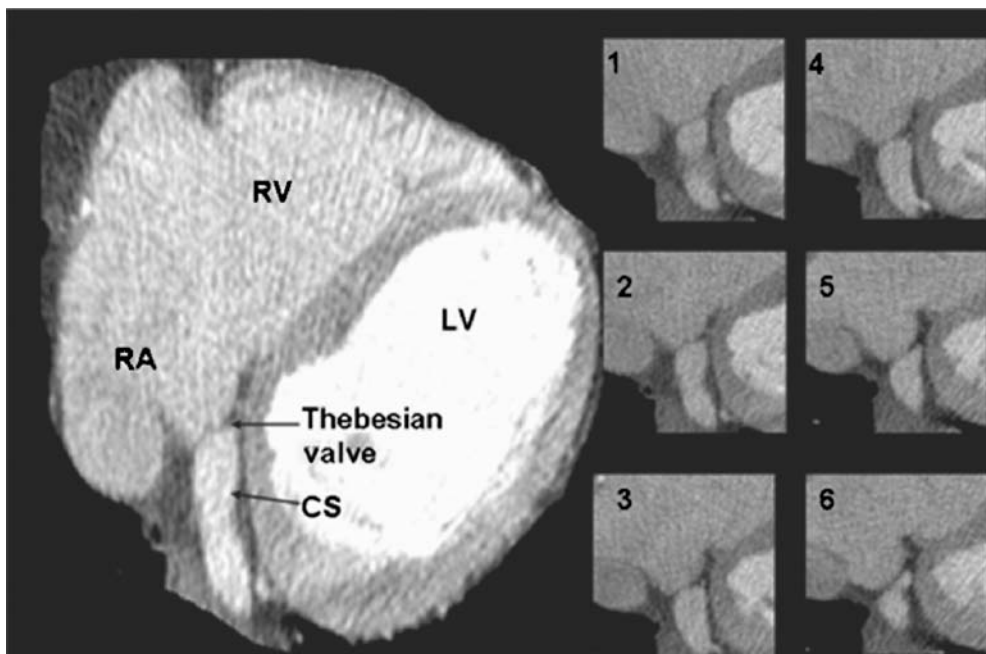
Serial CT angiography axial images at the coronary sinus os level, numbered from superior to inferior, demonstrating a prominent Thebesian valve (coronary sinus os valve) on all slices. CS = coronary sinus, RA = right atrium, RV = right ventricle, and LV = left ventricle. (Reprinted from: Shinbane JS, Ginsky MJ, Mao S, Budoff MJ. Thebesian valve imaging with electron beam CT angiography: implications for resynchronization therapy. *Pacing Clin Electrophysiol* 2004;27: 1566–1567, with permission from Blackwell Publishing, USA.)
